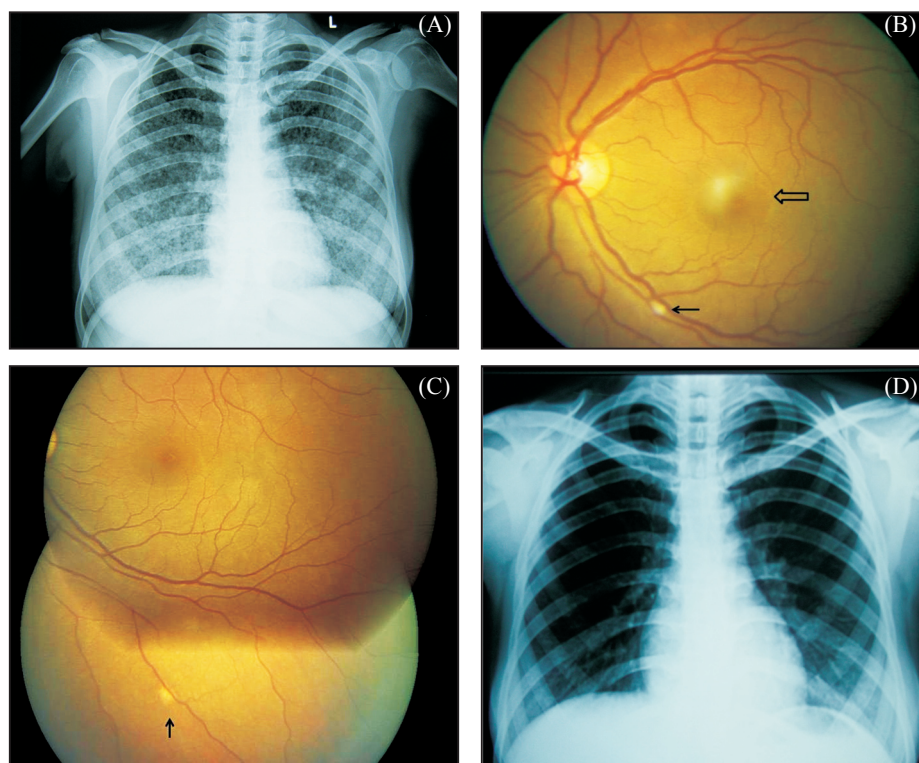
(A) Chest radiograph showing bilateral, diffuse small lung nodules suggesting miliary tuberculosis. (B) Fundus photograph of left eye showing yellowish white, active choroidal lesion (thick arrow) with hazy margins along inferior arcade and elevated foveolar lesion (thin arrow) suggestive of neurosensory detachment of retina (secondary to active choroidal lesion). (C) Fundus montage of left eye showing whitish, healed choroidal lesion (arrow) with discrete margins 6 months post treatment. (D) Chest radiograph showing complete resolution of miliary shadow.
